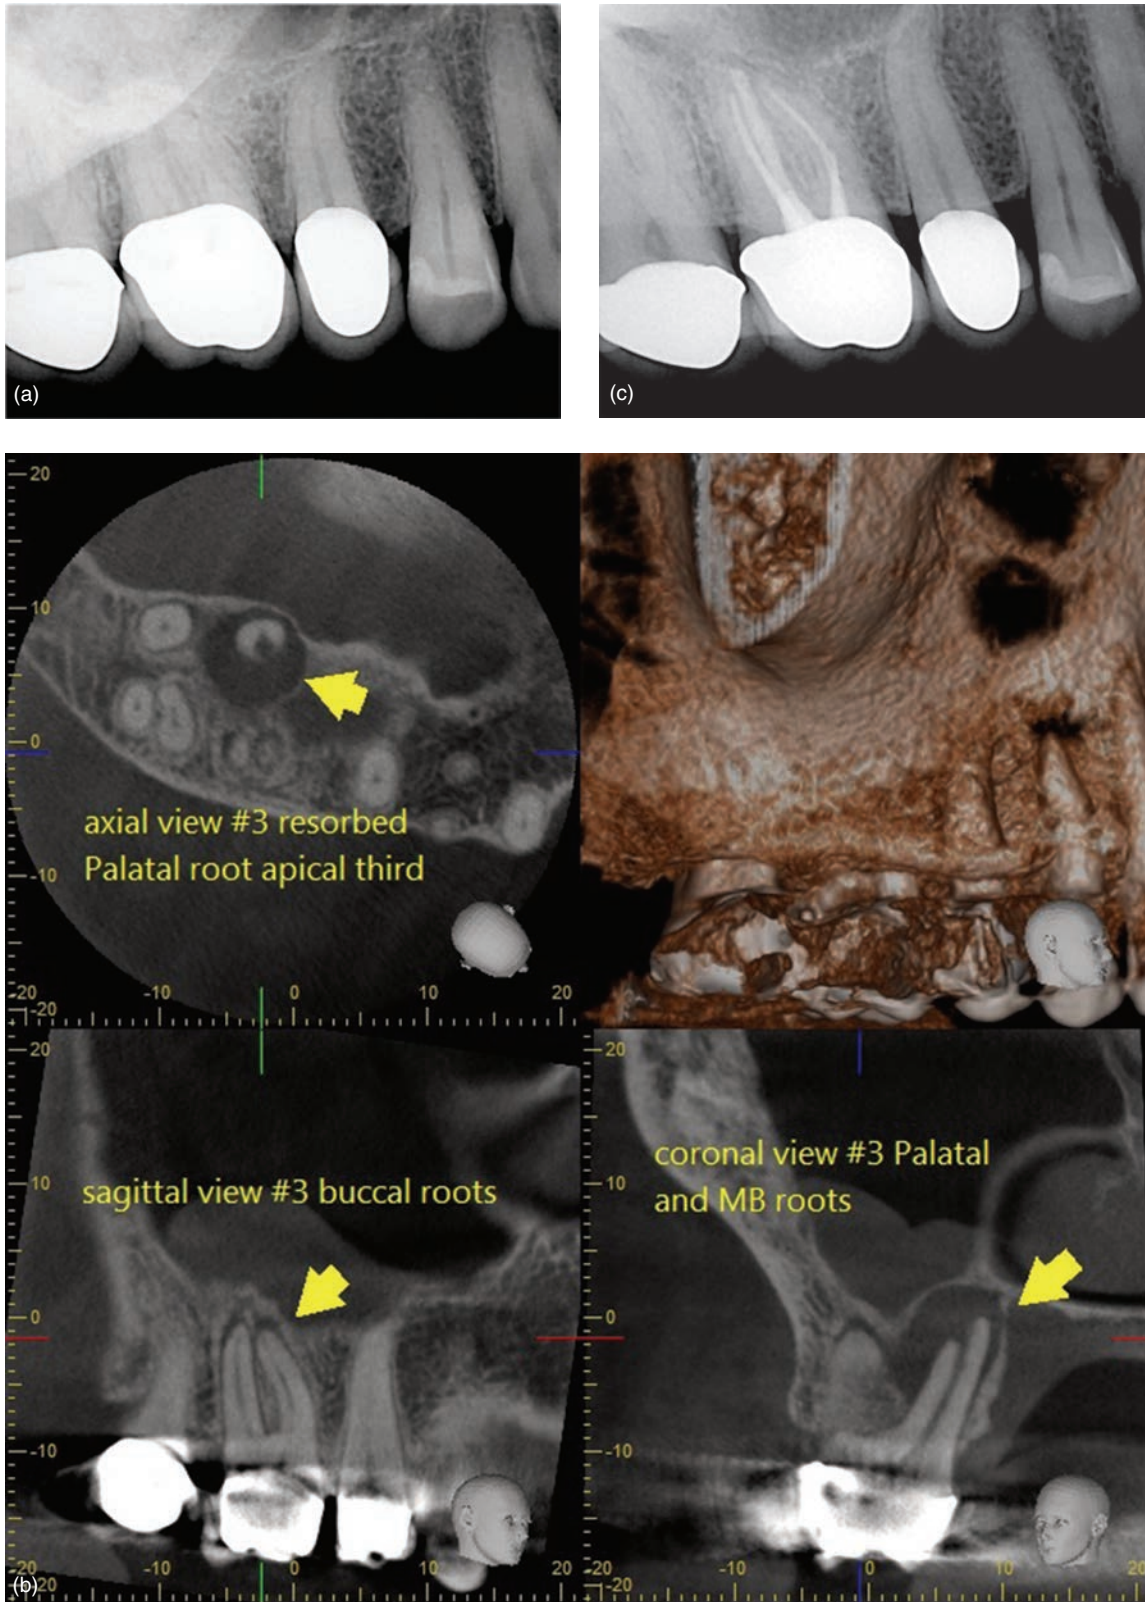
Palatal surgery maxillary right first molar. (a) Radiograph showing maxillary first molar requiring root canal treatment. (b) CBCT images showing a large low-density area around the palatal root and resorbed apex of the palatal root. (c) Postop palatal apico.
